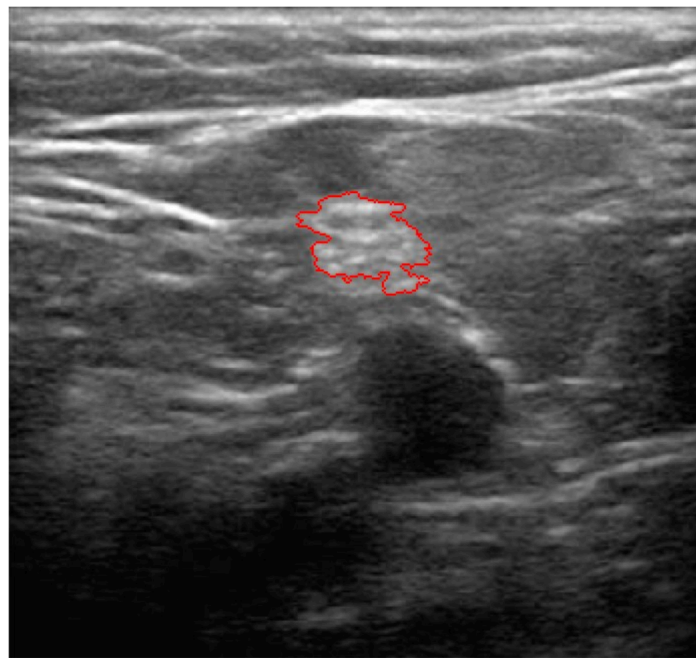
Region boundaries set by anatomical landmarks on an ultrasound image in the sciatic region: skin & fascia at top and vessels at bottom.
